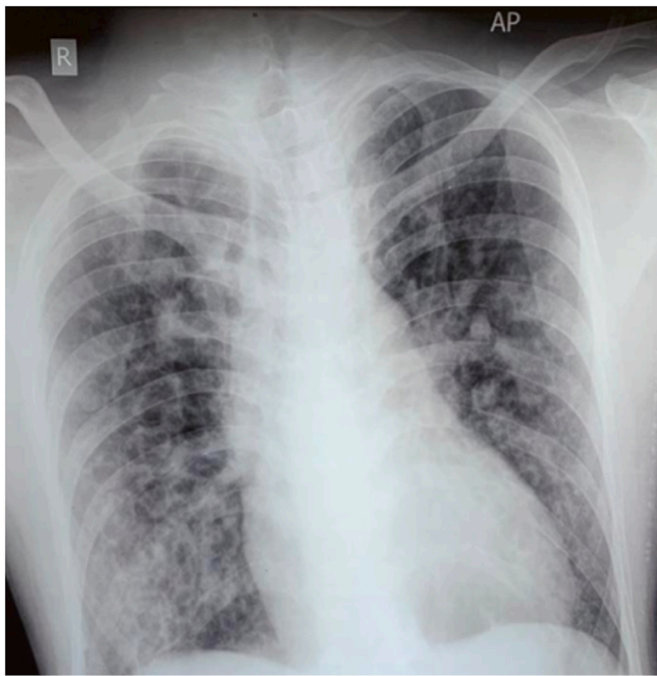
Chest X-ray showed reticulogranular patterns found in the right and left paracardial areas, accompanied by fibroinfiltrates on both sides of the lung.
